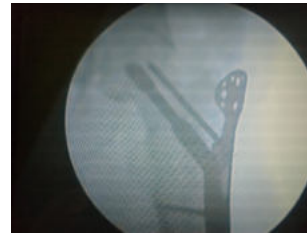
Final radiograph in AP view
